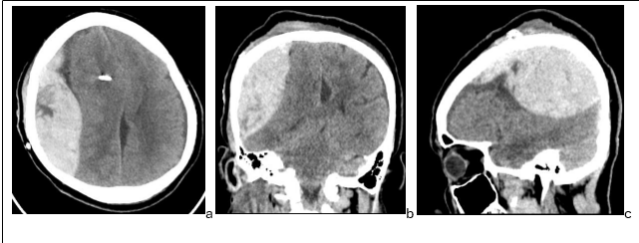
Post operative cranial CT scan; a. Axial view, b. Coronal view, c. Sagittal view.
